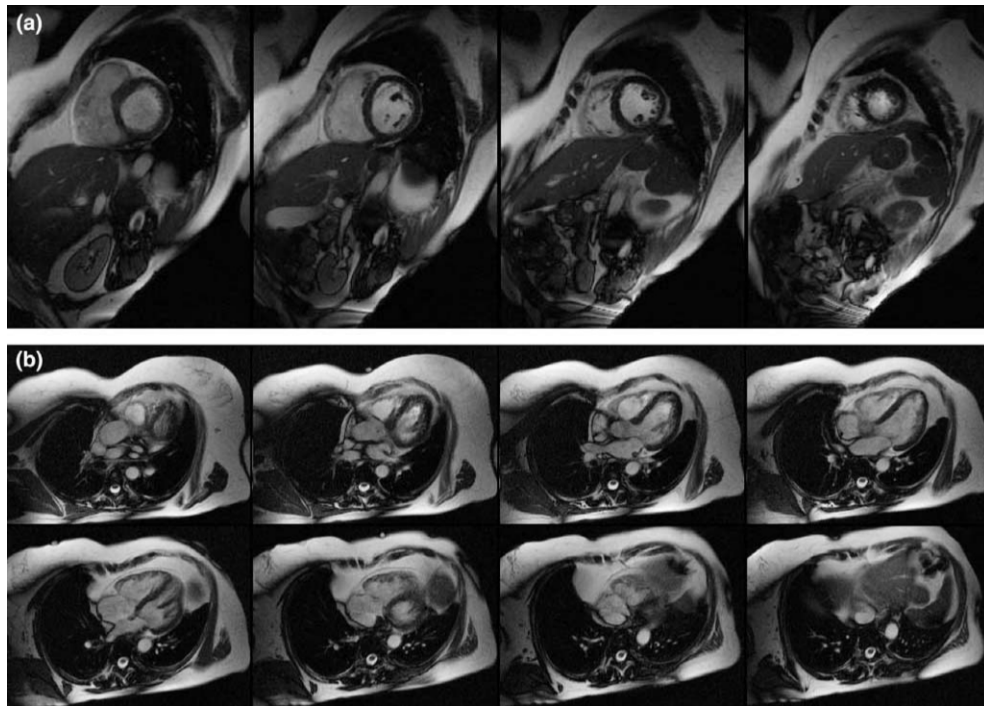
Original MR images of one subject: (a) SA images and (b) LA images.
